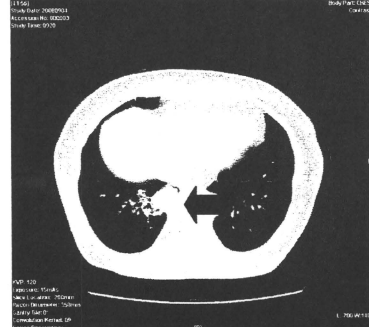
(d) 2008年検診 (HRCT)
